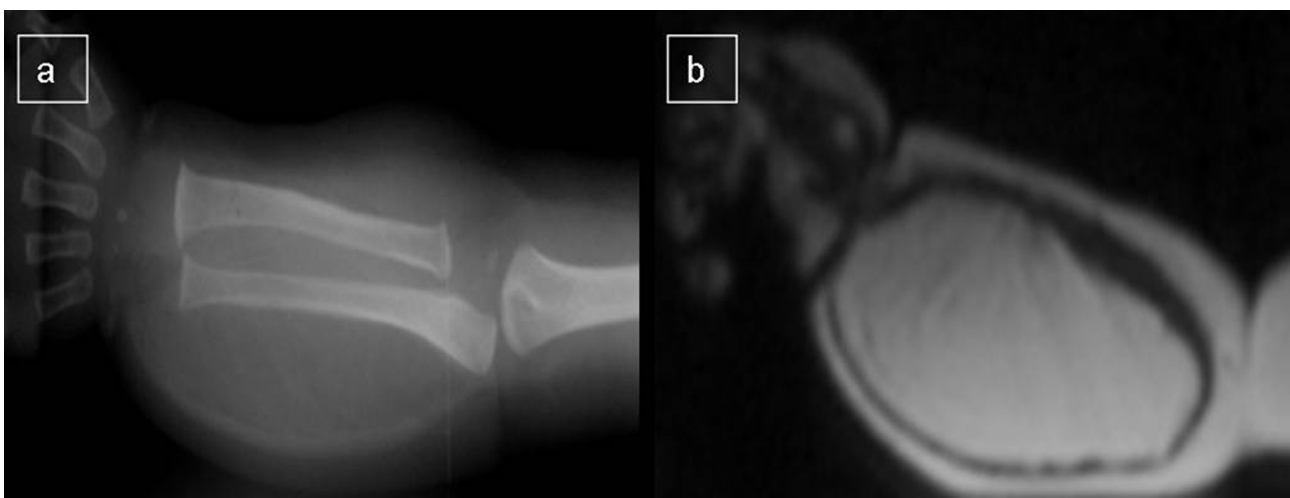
Large deep mass of the right forearm in a 7-month-old boy. a) Standard radiograph showing a large soft tissue mass in the muscular plane pushing against the ulna. b) Coronal MR T1-weighted image showing the high signal intensity mass replacing the anterior-internal muscles of the right forearm.
